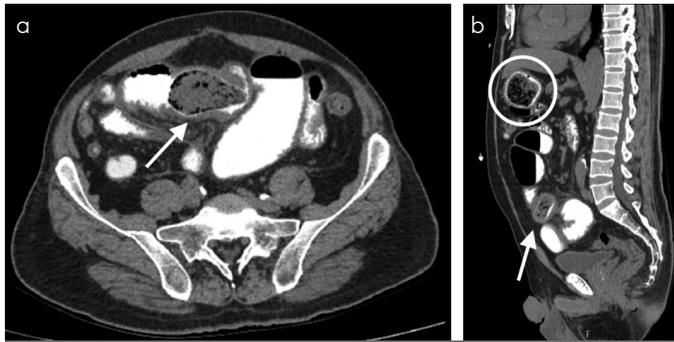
a, b. a. Axial b. Sagittal CT examinations with oral positive contrast material show a well-defined, lobulated nodular intestinal lesion including millimetric air densities compatible with phytobezoars and intestinal content impaction at the proximal part of small intestines accompanied by diffuse intestinal wall thickening and mesenteric heterogeneity (Arrow). The site of this impaction was defined as the transition zone of mechanical intestinal obstruction. Additionally, similar nodular density is observed in the stomach lumen (Circle)
